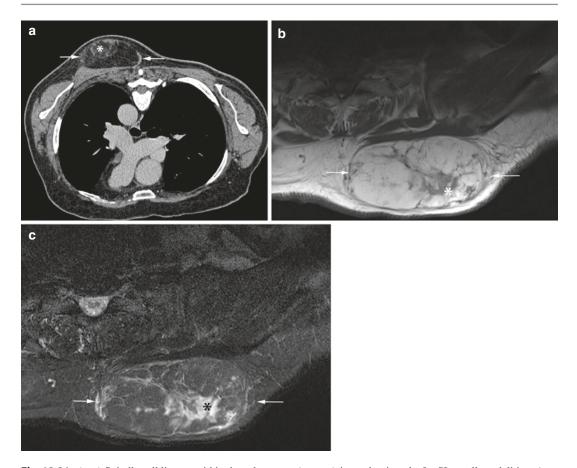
(a–c) Spindle cell lipoma within the subcutaneous tissues of the left back. (a) Axial CT image. (b) Axial SE T1-weighted MR image. (c) Axial FS TSE T2-weighted MR image. The signal intensity of the lesion
